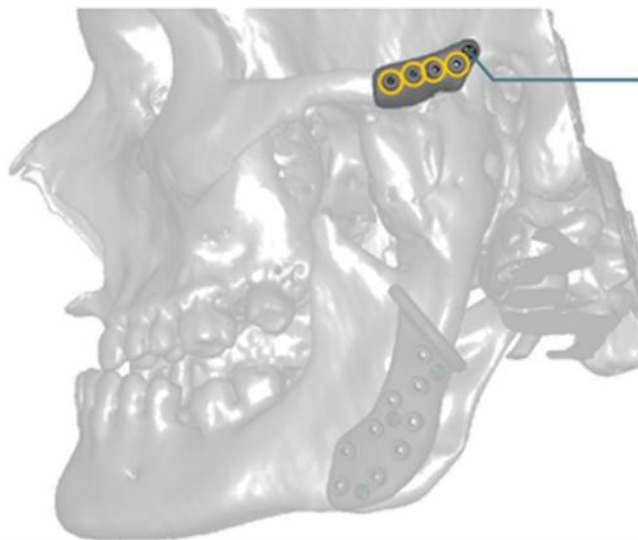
Project of TMJ fossa template placed over a 3D computed tomography reconstruction. A trial template positioned and fixed to the temporal bone with one 1.5 x 6.0 mm screw (indicated by blue line).
